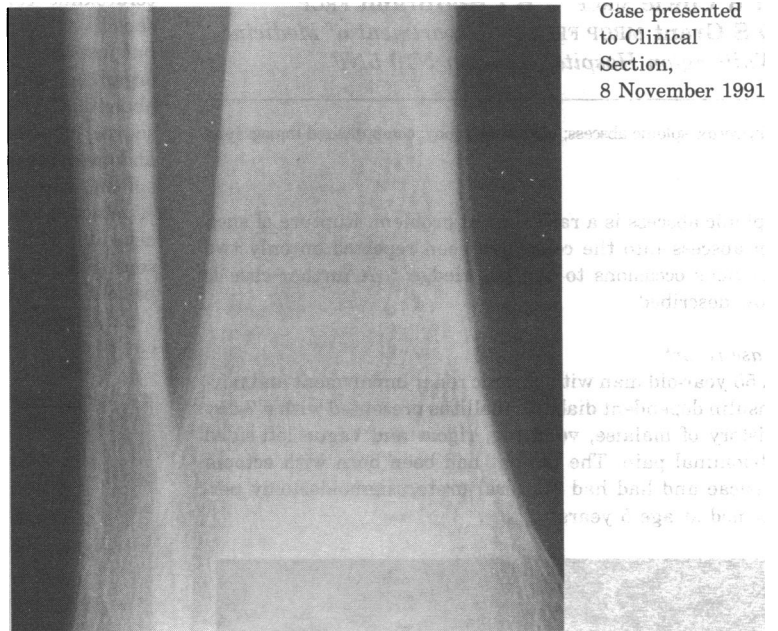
Lower tibial shaft with typical X-ray appearance of HPOA
